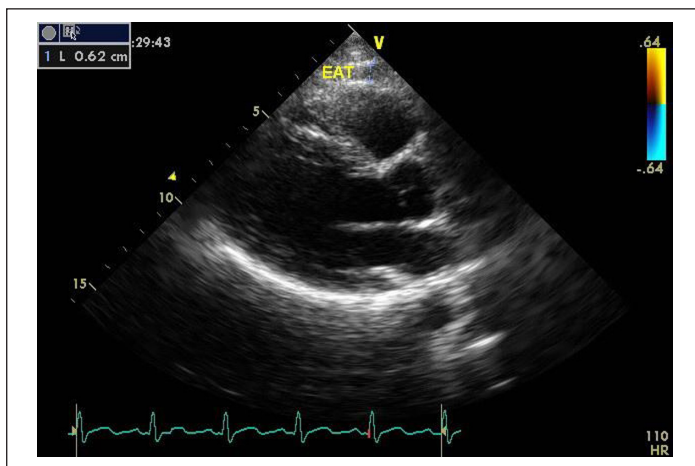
The measurement of EAT thickness on transthoracic echocardiography.
